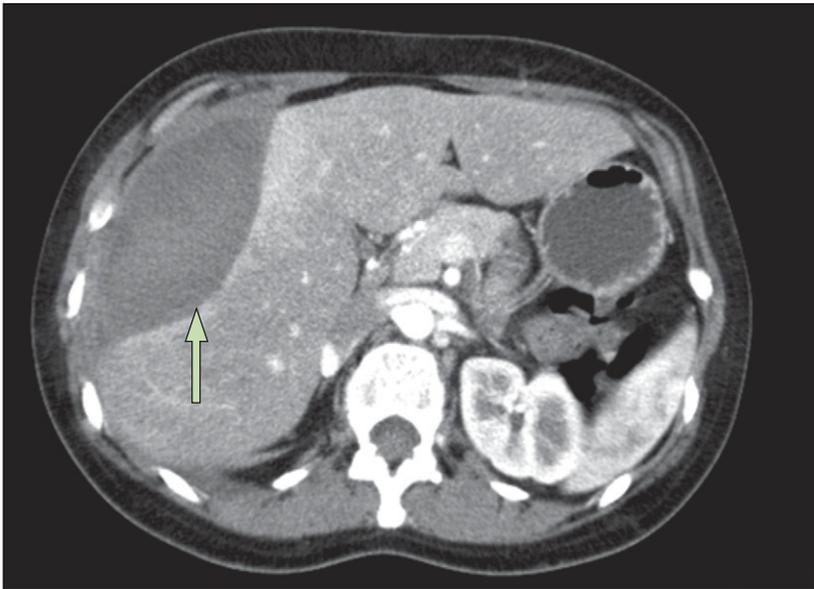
Abdominal CT showing a subcapsular haematoma in a woman with HELLP syndrome
